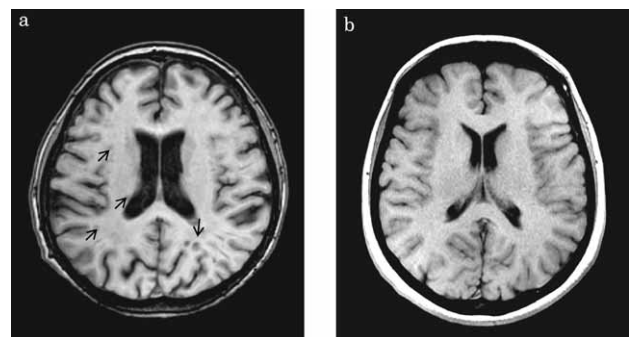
Axial T1-weighted MR images in multiple sclerosis patients confirmed as a) arylsulfatase A mutations carrier and b) arylsulfatase A mutations non-carrier, matched for age, gender and disease duration. Note white matter »black holes« (marked by arrows) in a) patient with mutations.
